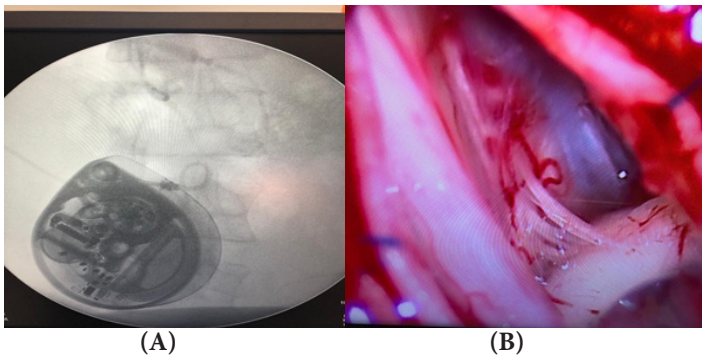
[A]: BACLOFEN PUMP: showing an intro-op X-ray showing placement of the baclofen reservoir with the spine in the background and the catheter placed above in the midline. This procedure works well in patients who respond to Baclofen consumed orally.
